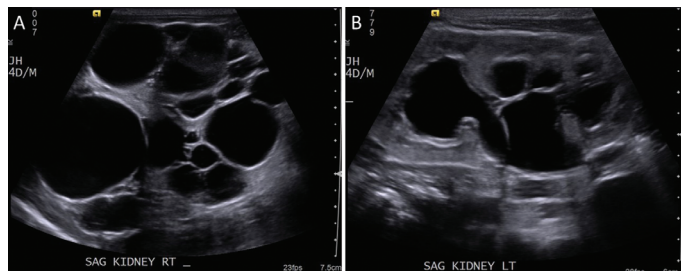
Renal ultrasound of 4-day-old male with right MCDK (A) and left urinary tract dilatation (B). Note communication of left upper pole dilatation with renal pelvis (B), distinguishing this from noncommunicating cysts of variable size (A).
